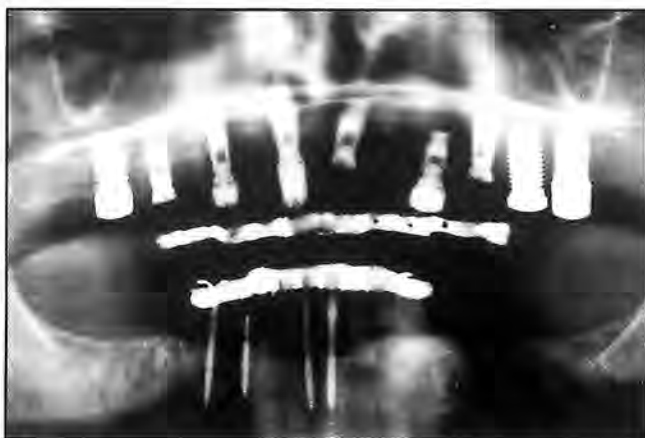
Panoramic radiograph demonstrates the initial placement of implants supporting the fixed splints. All TIs were removed and additional implants were placed.
